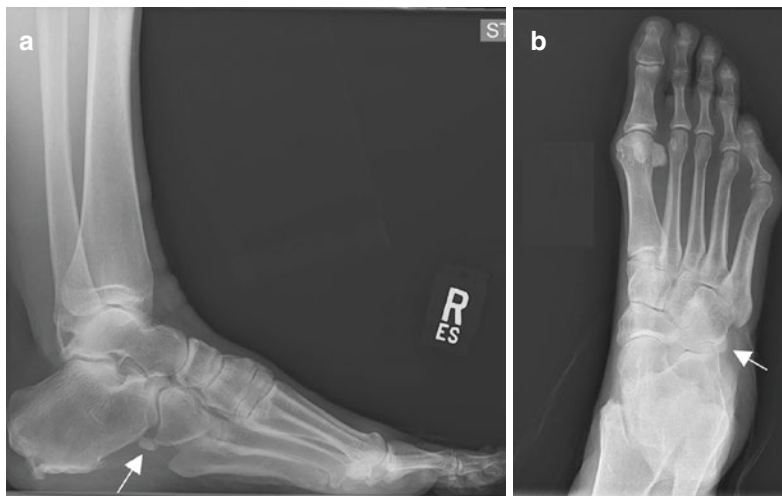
Plain film radiographs of a proximally migrated os peroneum (arrow). (a) Lateral view. (b) 45-degree internal rotation oblique view. (Used with permission from James W. Brodsky, M.D. Baylor University Medical Center, Dallas, USA)
